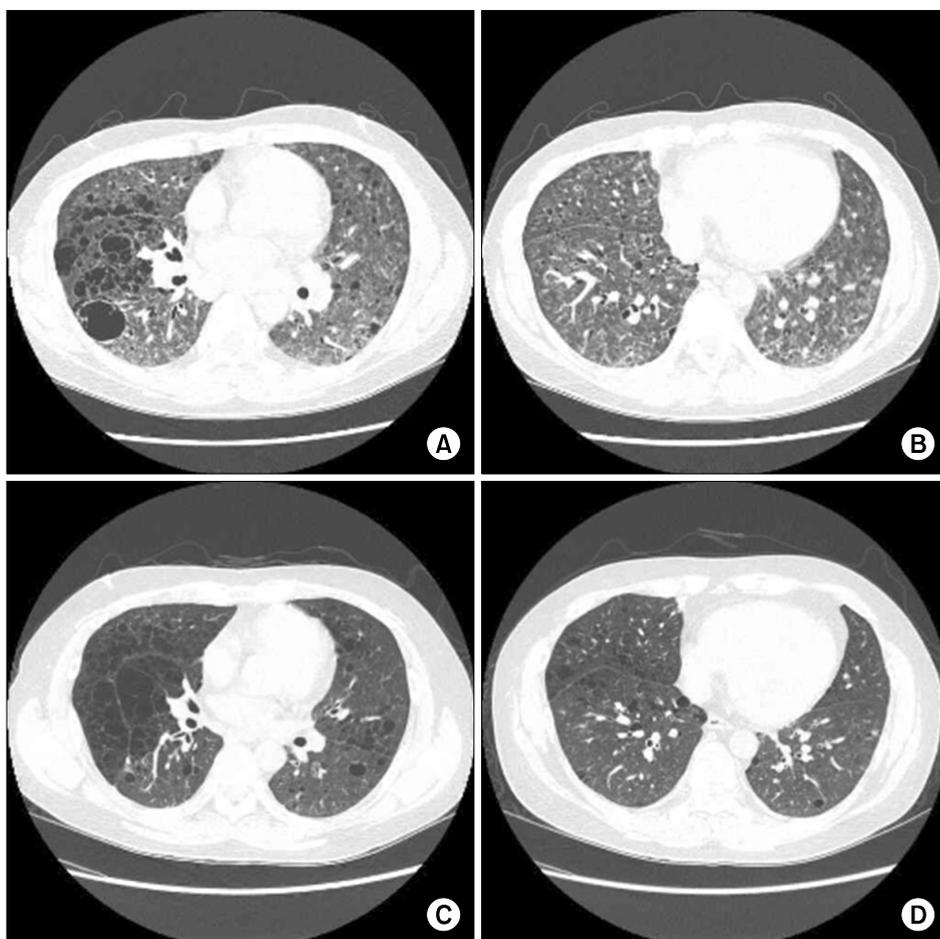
(A) Multiple cysts are found in various sizes on both upper and middle lobes of lung accompanied by multiple lymphadenopathy. (B) Small sized centrilobular nodules are found mainly on both lower lobes of lung. (C) HRCT taken 6 months after auto SCT. Inflammation was improved on both lung field, size and number of lymphadenopathy were all decreased. (D) Both size and number of centrilobular nodules presented on both lung fields were all decreased.
